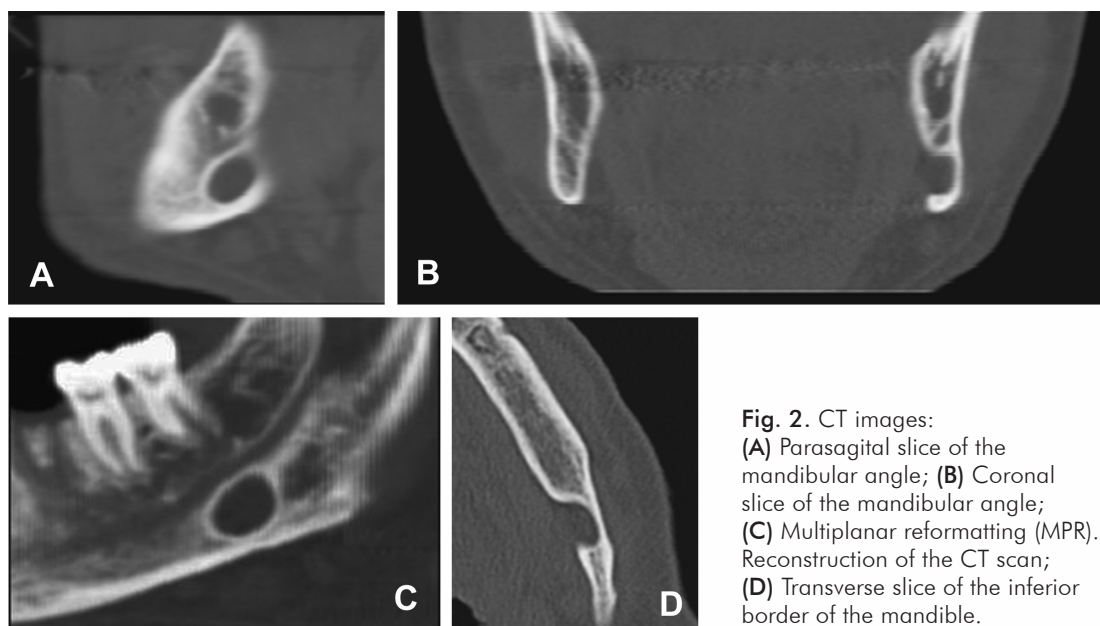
CT images: (A) Parasagittal slice of the mandibular angle; (B) Coronal slice of the mandibular angle; (C) Multiplanar reformatting (MPR). Reconstruction of the CT scan; (D) Transverse slice of the inferior border of the mandible.
